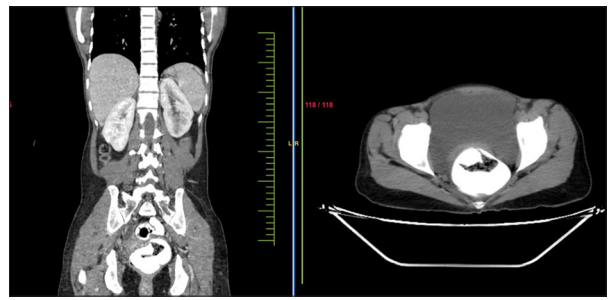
Contrast-enhanced computed tomography scan showing circumferential wall thickening at the rectosigmoid junction with luminal narrowing and proximal colonic dilatation suggestive of distal colonic obstruction
